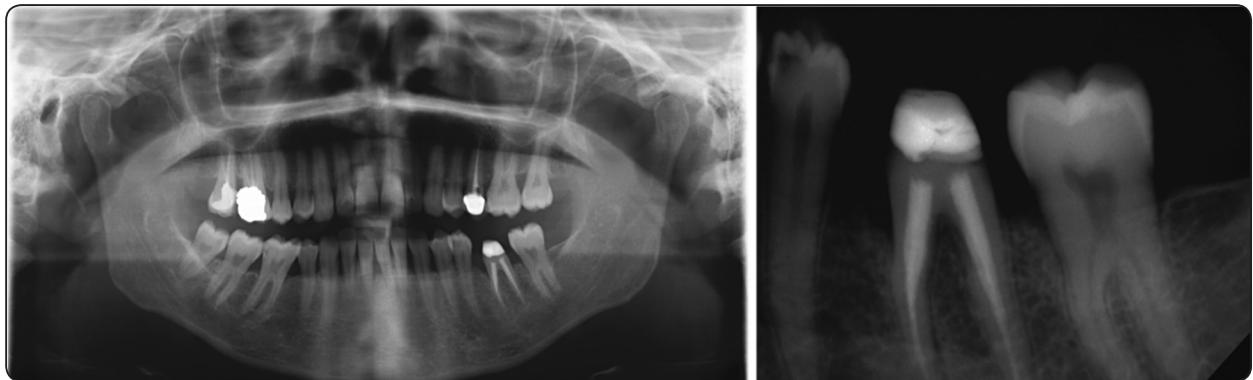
Orthopangraph and Periapical radiograph showing tooth #36. There is a mild horizontal bone loss, coronal restoration with evidence of leakage and root filling material.
